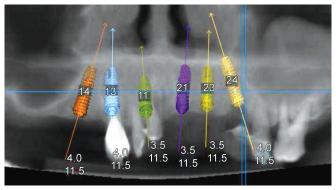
Presurgical dimensional and angulation analysis (CBCT) of the anterior maxillary region wherein multiple implants are to be placed (implant supported arch rehabilitation). Note the different length, width, and angulations of virtually positioned implants as per available bone and adjacent maxillary sinus lining
